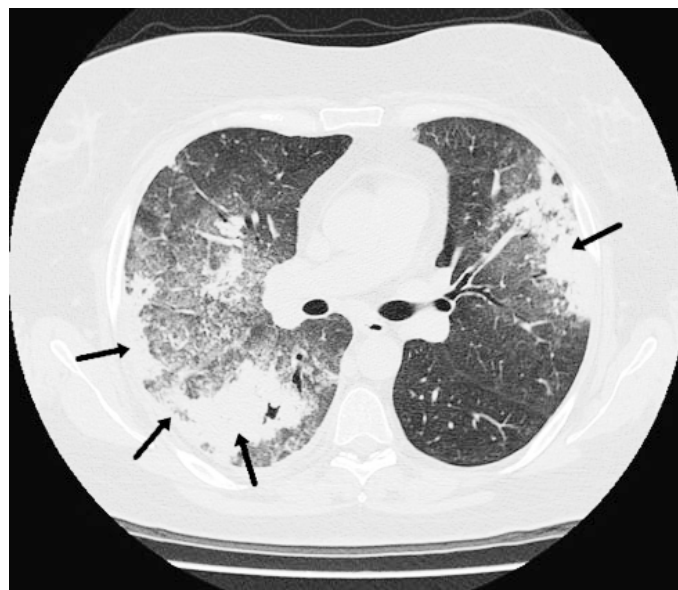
Churg-Strauss syndrome. Thin section CT scan at carina shows multifocal patchy ground-glass opacity around the patchy consolidation showing halo sign (arrows).
